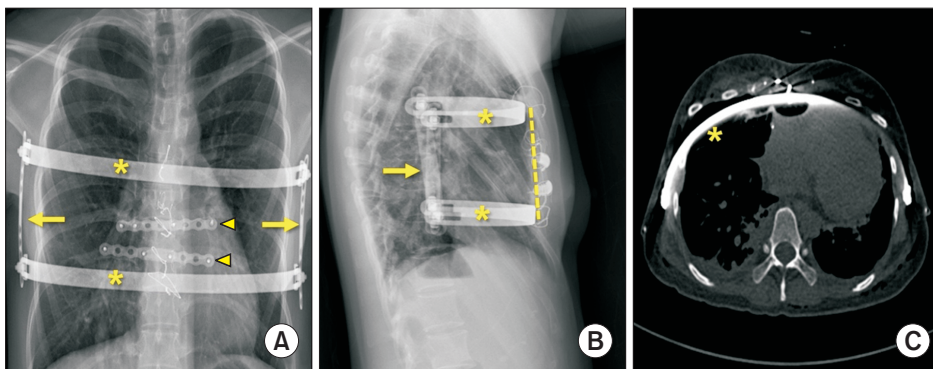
(A, B) Outpatient chest X-ray revealing correction of the pectus excavatum (PE). The asterisk (*) symbols represent the parallel pectus bars, the arrows represent the bridge plate, and the arrowheads represent the rib-locking plates. (C) Postoperative day 3 chest computed tomography showing correction of the PE with a decrease in the Haller index from 5.64 to 2.76.
